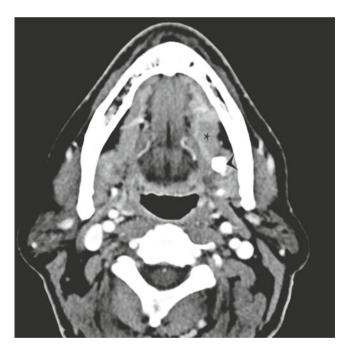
Submandibular sialolith. Axial contrast-enhanced CT demonstrates a large left submandibular sialolith (*arrowhead*) with associated ductal dilatation (*asterisk*)
